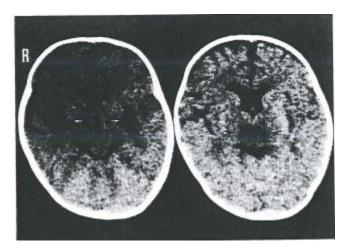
In the CT scans conducted on October 7, clear areas of low density are visible in both the thalami (indicated by arrowheads) and the putamen (marked by arrows) on both sides of the brain.
